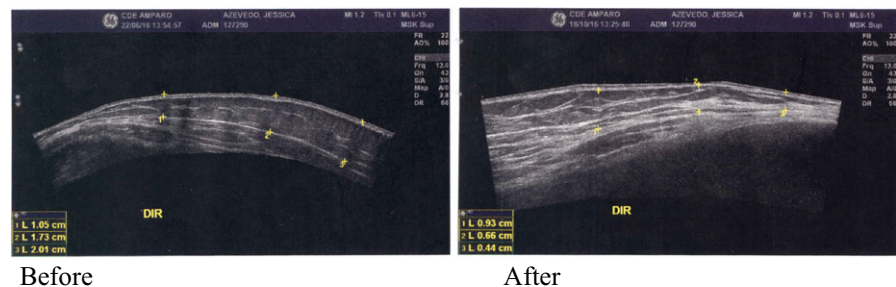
Comparison of ultrasonography before and after right-hand intervention—Volunteer 1FIGURE 2 Comparison of ultrasonography before and after right-hand intervention—Volunteer 2
